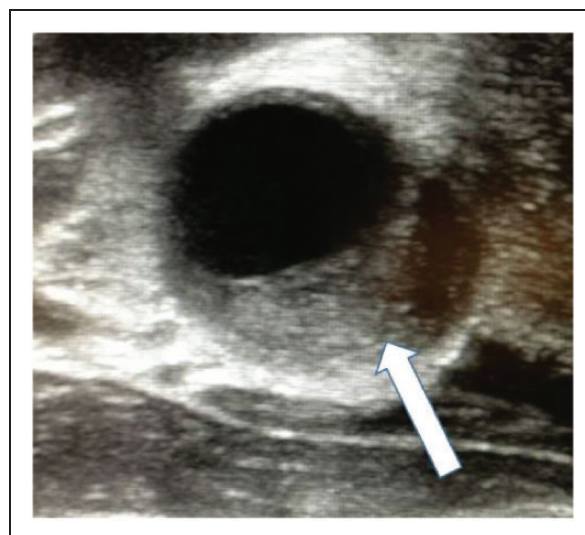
Duplex ultrasound of the carotid artery showing perivascular inflammatory tissue density (arrow) surrounding the internal carotid artery.
